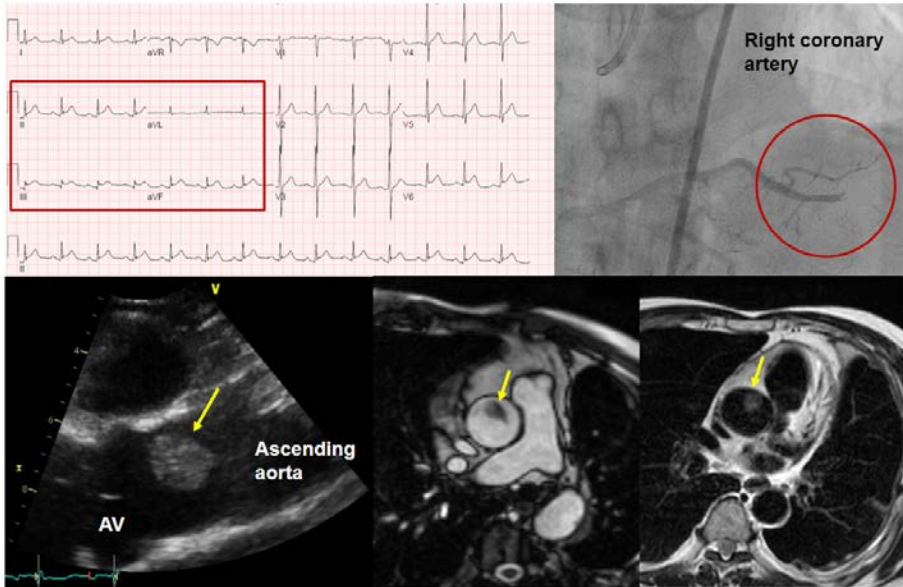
A case of a 67 year old man with a diagnosis of metastatic mesothelioma. Cisplatin based chemotherapy had been started one month earlier. The patient was experiencing acute chest pain at rest for one hour with ST segment elevation on the inferior leads. Thrombotic occlusion at the distal right coronary artery was shown on the coronary angiogram. A round hypermobile mass on the ascending aorta was seen on the echocardiogram, compatible with a thrombus on CMR imaging (iso-signal intensity on T1 weighted imaging, slightly high signal intensity on T2 weighted imaging).
